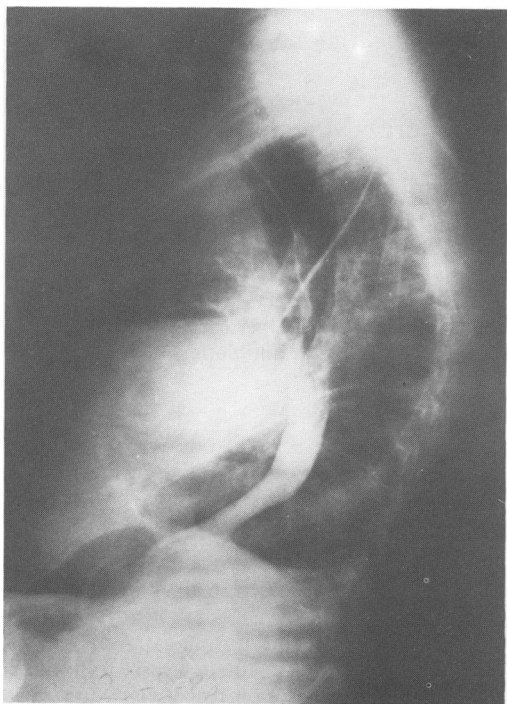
Lateral chest roentgenogram after ditrizoate methylglucamine (Gastrografin) swallow without evidence of fistula.
